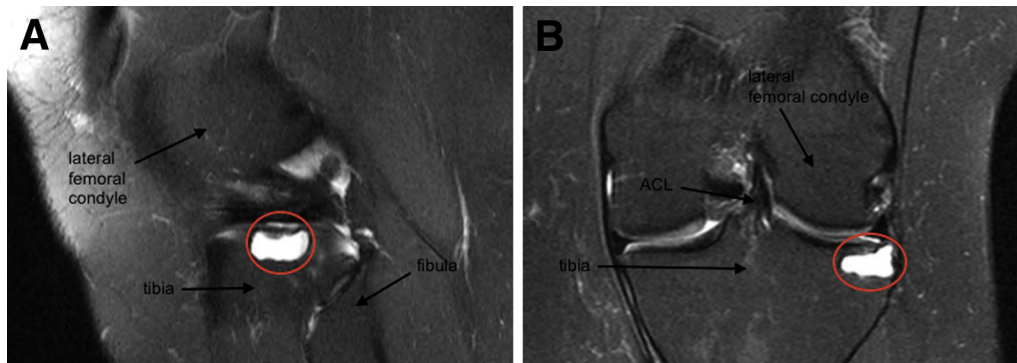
Left knee magnetic resonance image, fat-saturated T2. (A) Sagittal plane shows a hyperintense lesion on the proximal lateral tibial (red circle), described as a cystic change by the radiology report. (B) Coronal view of the lesion (red circle) shows the vicinity to the tibial plateau with concern of its integrity. The arthroscopic view can properly evaluate whether the plateau is collapsed or not, and based on this the surgical procedure can be changed.
